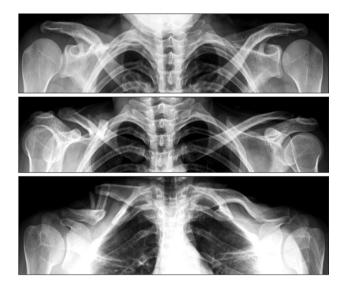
A 20-year-old woman injured in a sports accident (Judo). Simple radiographs showed a comminuted segmental fracture of the clavicle (Robinson classification, 2B2).
